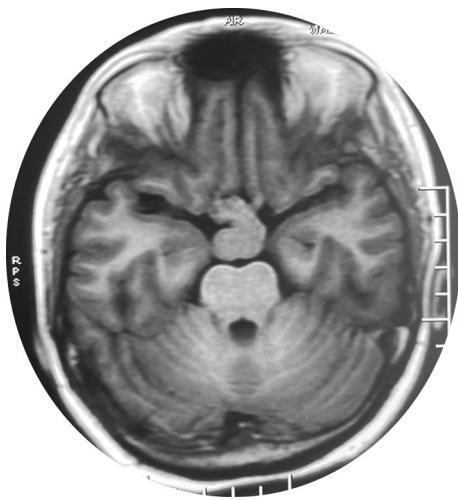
MRI brain T1 axial image showing slightly hyperintense lesion in the suprasellar area
